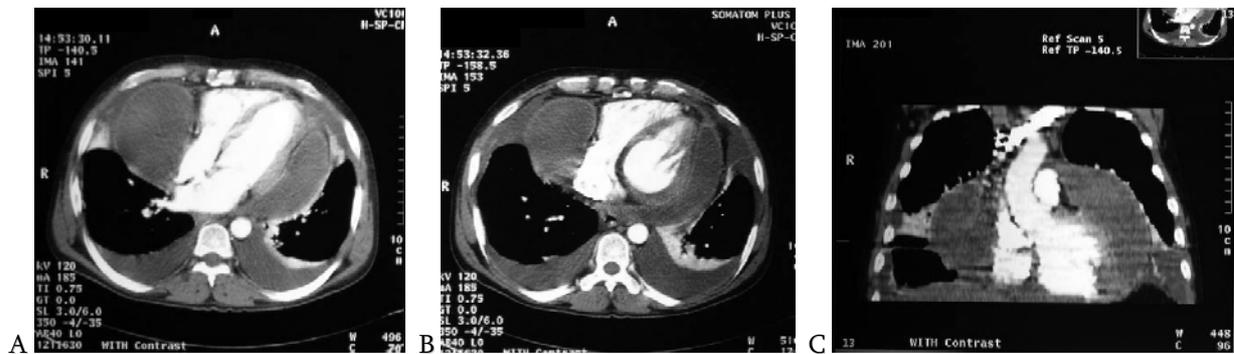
A,B Cardiac CT angiography ,with coronal reconstruction (C)
